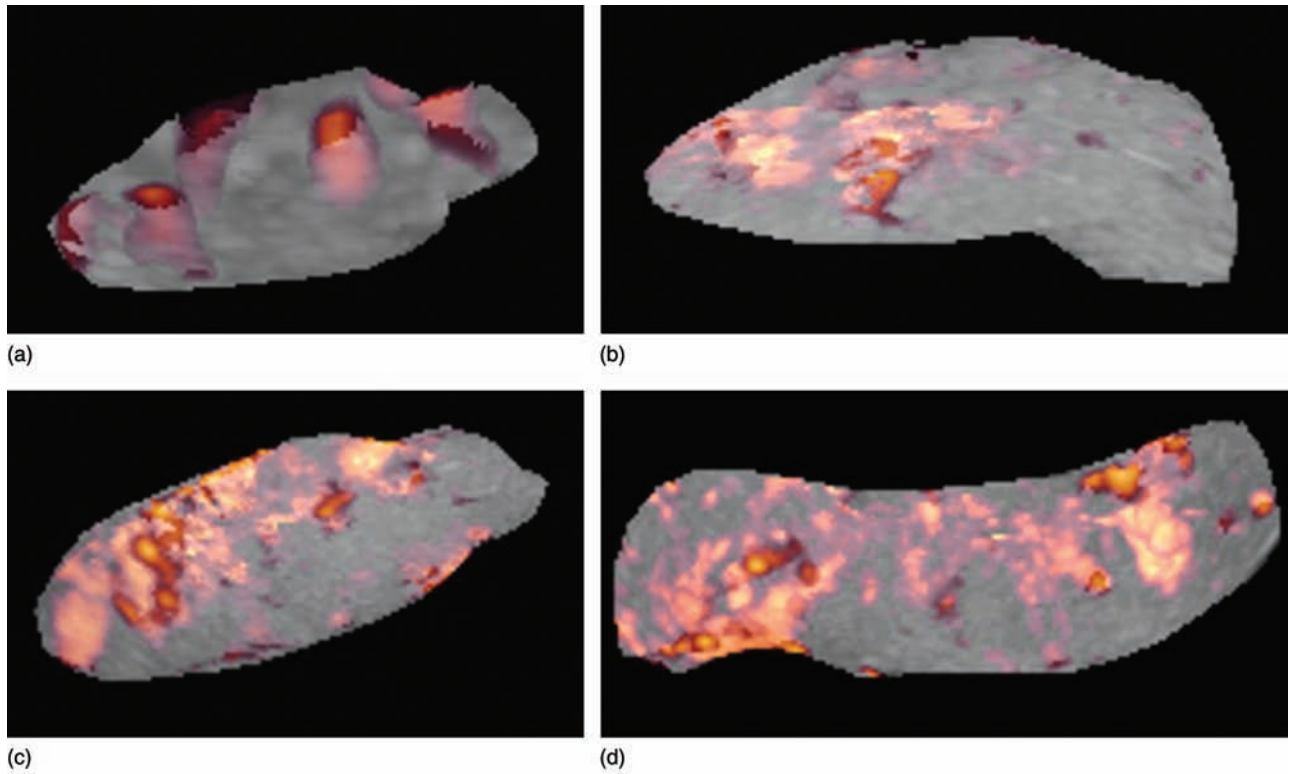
3D power Doppler angiography of the intervillous flow at 6 weeks (a), 8 weeks (b), 10 weeks (c) and 12 weeks (d) of normal pregnancies.
